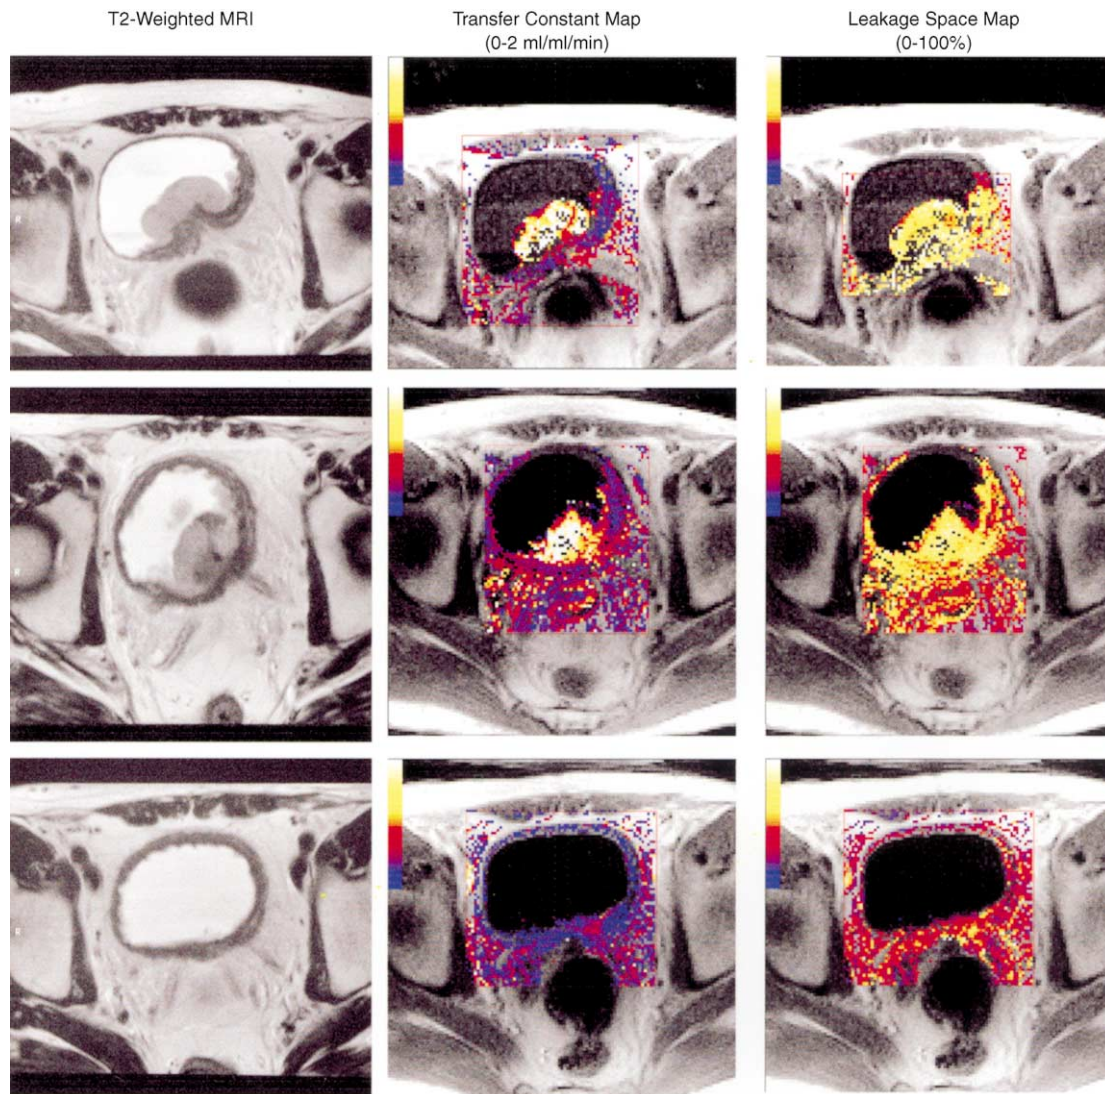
Monitoring radiotherapy response of bladder cancer with DCE-MRI. *Columns:* anatomical T2-weighted MR images of a transitional cell bladder carcinoma, transfer constant maps (colour display range 0–2 ml/ml/min) and leakage space maps (colour display range 0–100%) in a patient being treated with radiotherapy. *Top row:* Baseline images show that the bladder wall is markedly thickened, but has a low transfer constant suggesting that the thickening is not due to tumour infiltration. The stalk of the tumour has intermediate transfer constant values. A number of pixels within the tumour show no colour (modelling failures). Median tumour transfer constant value 1.39 ml/ml/min, leakage space values 70%, and rate constant value 1.98 ml/ml/min. *Middle row:* 30 days after starting radiotherapy (44 gray), the tumour has changed in shape, but continues to show high transfer constant values. The wall and fatty tissues around the bladder now show increased transfer constant (increased capillary permeability) and leakage space. These features are consistent with vascular damaging effects of radiotherapy. Median tumour transfer constant value 0.64 ml/ml/min, leakage space values 59%, and rate constant value 1.18 ml/ml/min. *Bottom row:* 30 days after the completion of treatment (total dose administered 60 gray), the tumour mass has almost completely regressed, but the bladder wall continues to be thickened. Marked reductions in transfer constant and leakage space are now observed. Median tumour transfer constant value 0.29 ml/ml/min, leakage space values 45%, rate constant value 0.66 ml/ml/min. (Reprinted by kind permission of W.B. Saunders and *Clinical Radiology* [16].)
